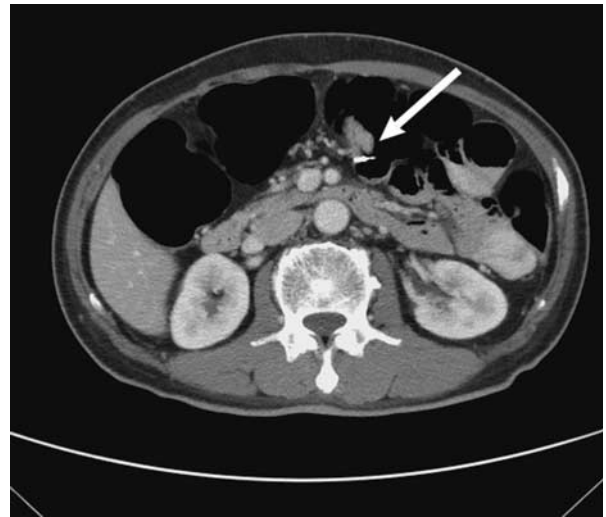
Preoperative abdominal computed tomography. The metallic clip was enhanced at the sigmoid colon.
